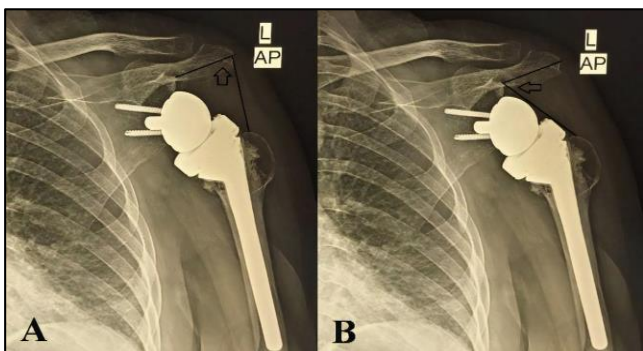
(A and B): Post-operative radiographs showing; LSA (black arrow), DSA (black arrow).
